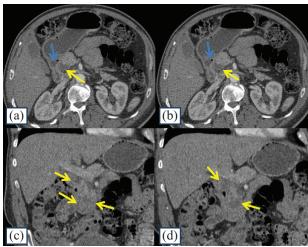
Abdominal CT scan axial (a, b) and coronal (c, d) images with contrast injection showing thickening of the inner wall of the second duodenum, lately enhanced (blue arrow), with multiple subcentimetric cystic formations in the wall of the duodenum and in the duodenopancreatic groove (yellow arrow).
